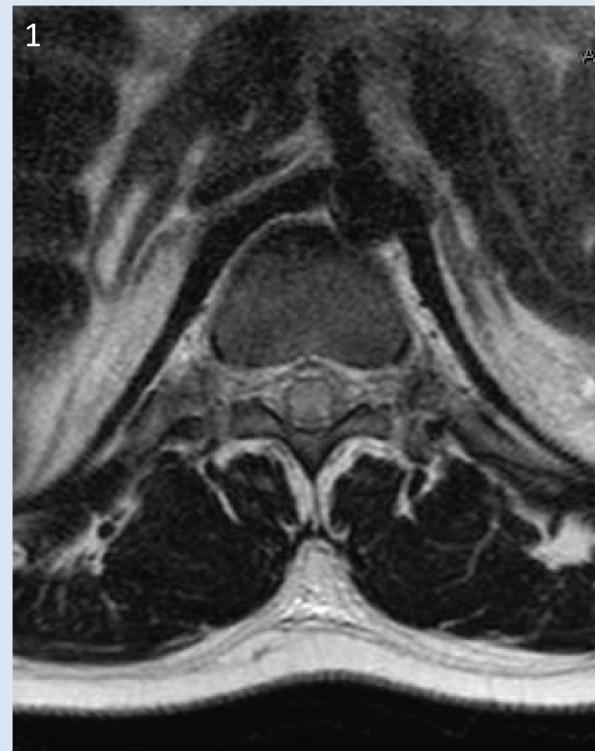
(left): T2-weighted axial MRI demonstrating almost entire involvement of transverse section of the spinal cord.
